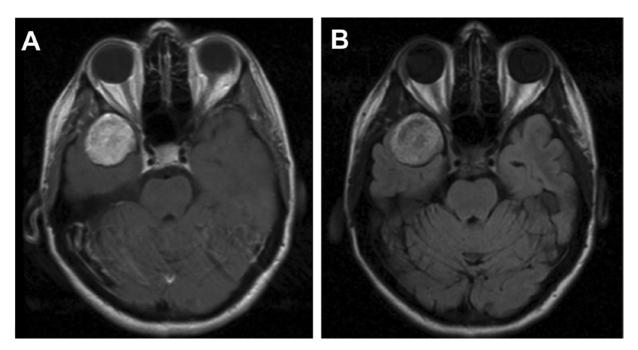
A. Magnetic resonance imaging in T1C+ – homogeneous and hyperintense mass in the right middle cranial fossa. B. T2 magnetic resonance imaging showing the same mass with a heterogeneous appearance.
